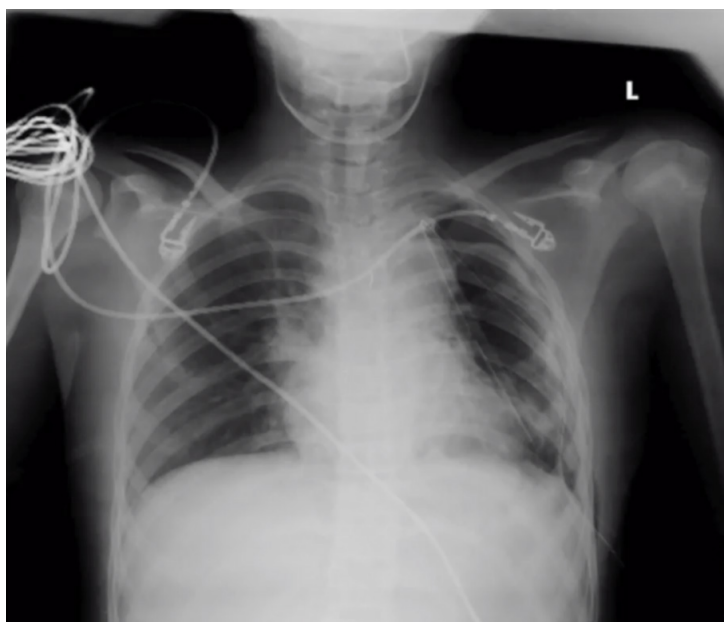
Postoperative chest X-Ray showing good inflation of the lung with no abnormalities
